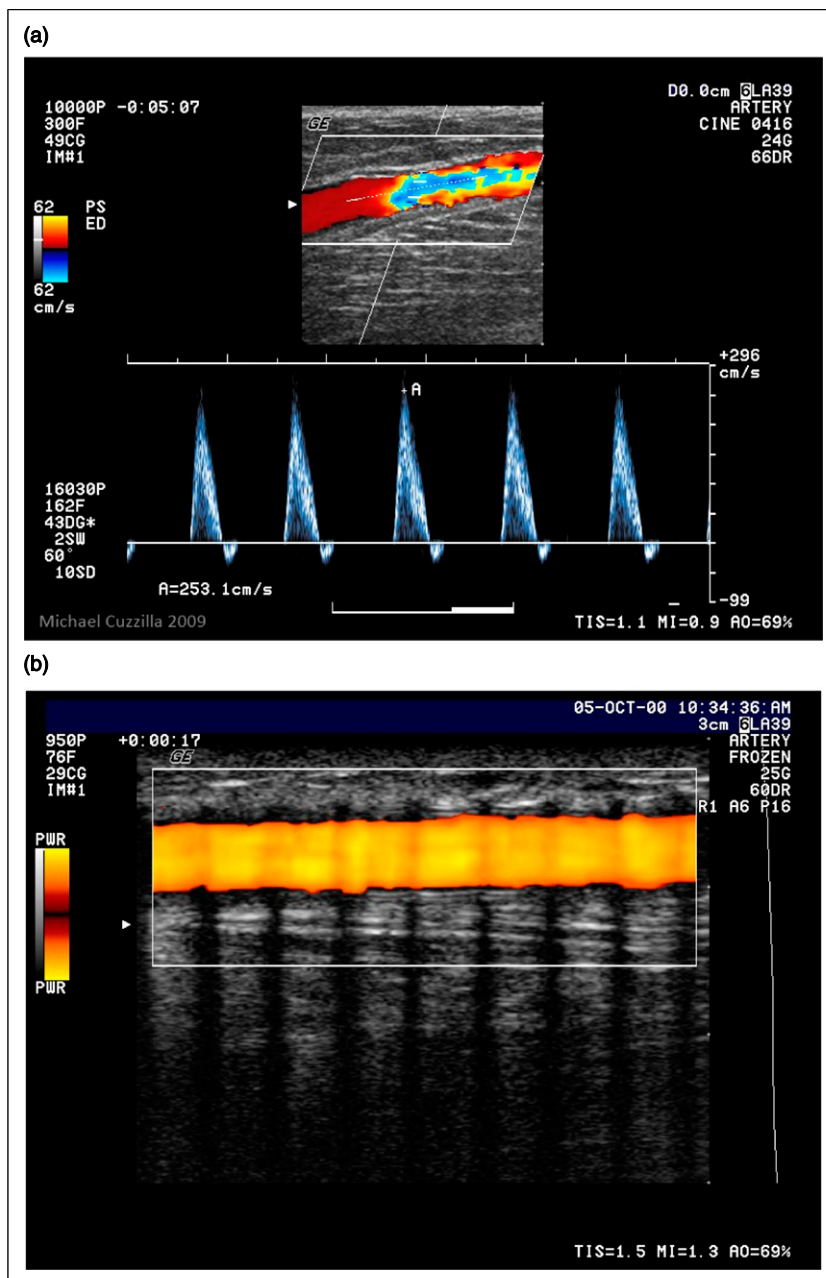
Superficial position of Femoral-popliteal Bypass Grafts (A) Spectral and colour Doppler of a stenotic femoral-popliteal vein graft demonstrating a superficial position in the right medial thigh. (B) Power Doppler of a femoral-popliteal synthetic bypass graft demonstrating a superficial position in the right medial thigh (ultrasound images courtesy of Michael Cuzzilla, Australia).
